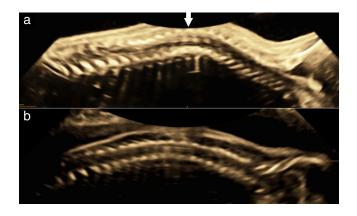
Subtle signs of congenital hypotonia on ultrasound imaging: spine deformity. (a) Thoracic kyphosis (arrow) in minicore myopathy (see also Videoclip S2), with (b) normal spine for comparison (see also Videoclip S3).
